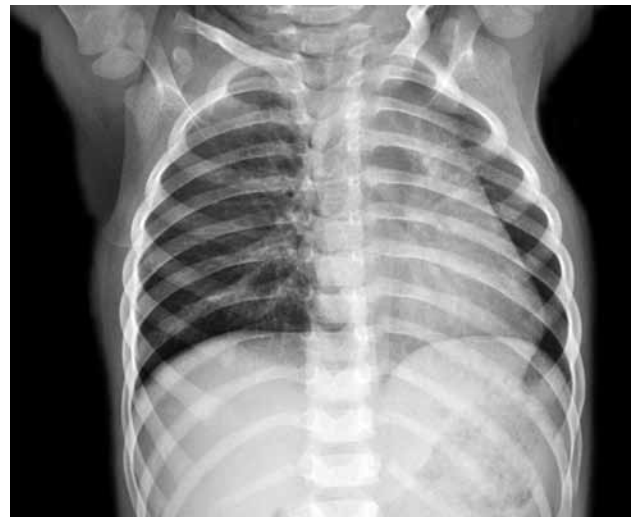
Chest X-ray showing hyperinflation on right side with shift of mediastinum to left side.
